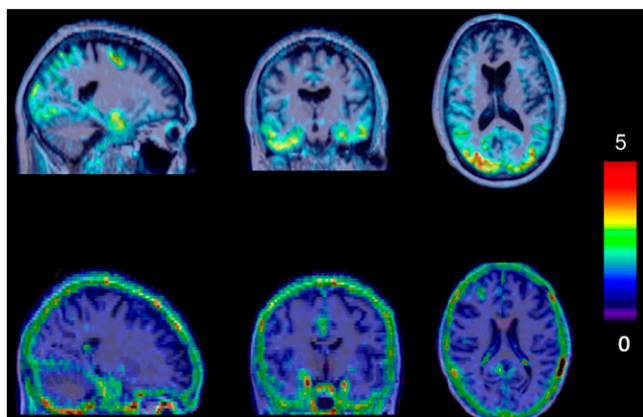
Longitudinal changes in reference region uptake and extracerebral signal of ^{18}F -MK-6240 PET. Example images from 2 individuals: (top row) with mild cognitive impairment (age, 60 y; MMSE = 23) and (bottom row) cognitively normal (age, 69; MMSE = 28). An extracerebral signal was present in about 50% of cognitively normal individuals, which can contaminate the cerebellar gray matter reference region and hamper tau quantification. The work emphasizes the importance of examining reference region SUVs in longitudinal studies involving cognitively normal subjects.
